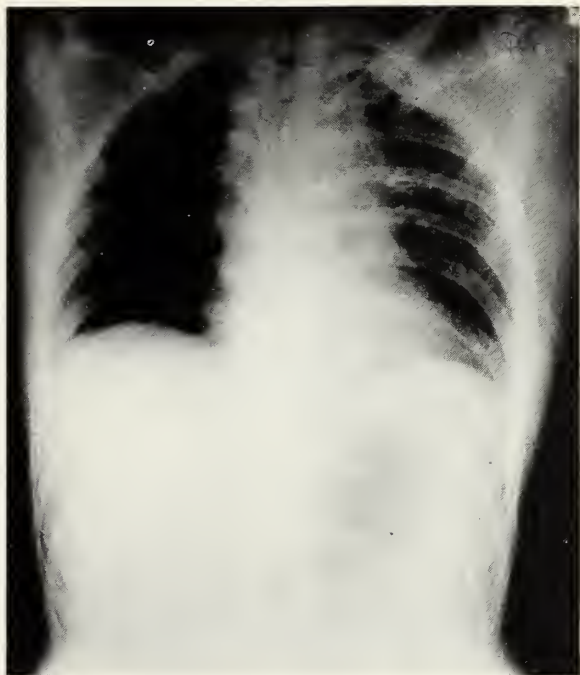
Portable supine chest x-ray taken in the emergency room after a chest tube was inserted. Note widened mediastinum and multiple fractured ribs posteriorly on the left side. A small apical hemopneumothorax persists on the left side.
